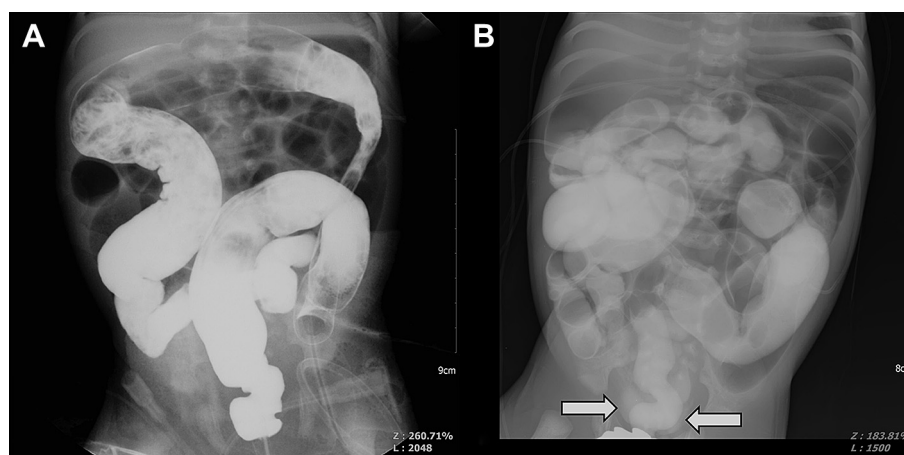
(A) A 4-day-old boy with abdominal distention. The colon study demonstrates multiple filling defects in descending and transverse colon, slowly refluxed into the proximal colon and terminal ileum by the pressure of injected contrast. (B) Supine abdominal radiograph taken 3 hours after the colon study demonstrated opacified urinary bladder.
